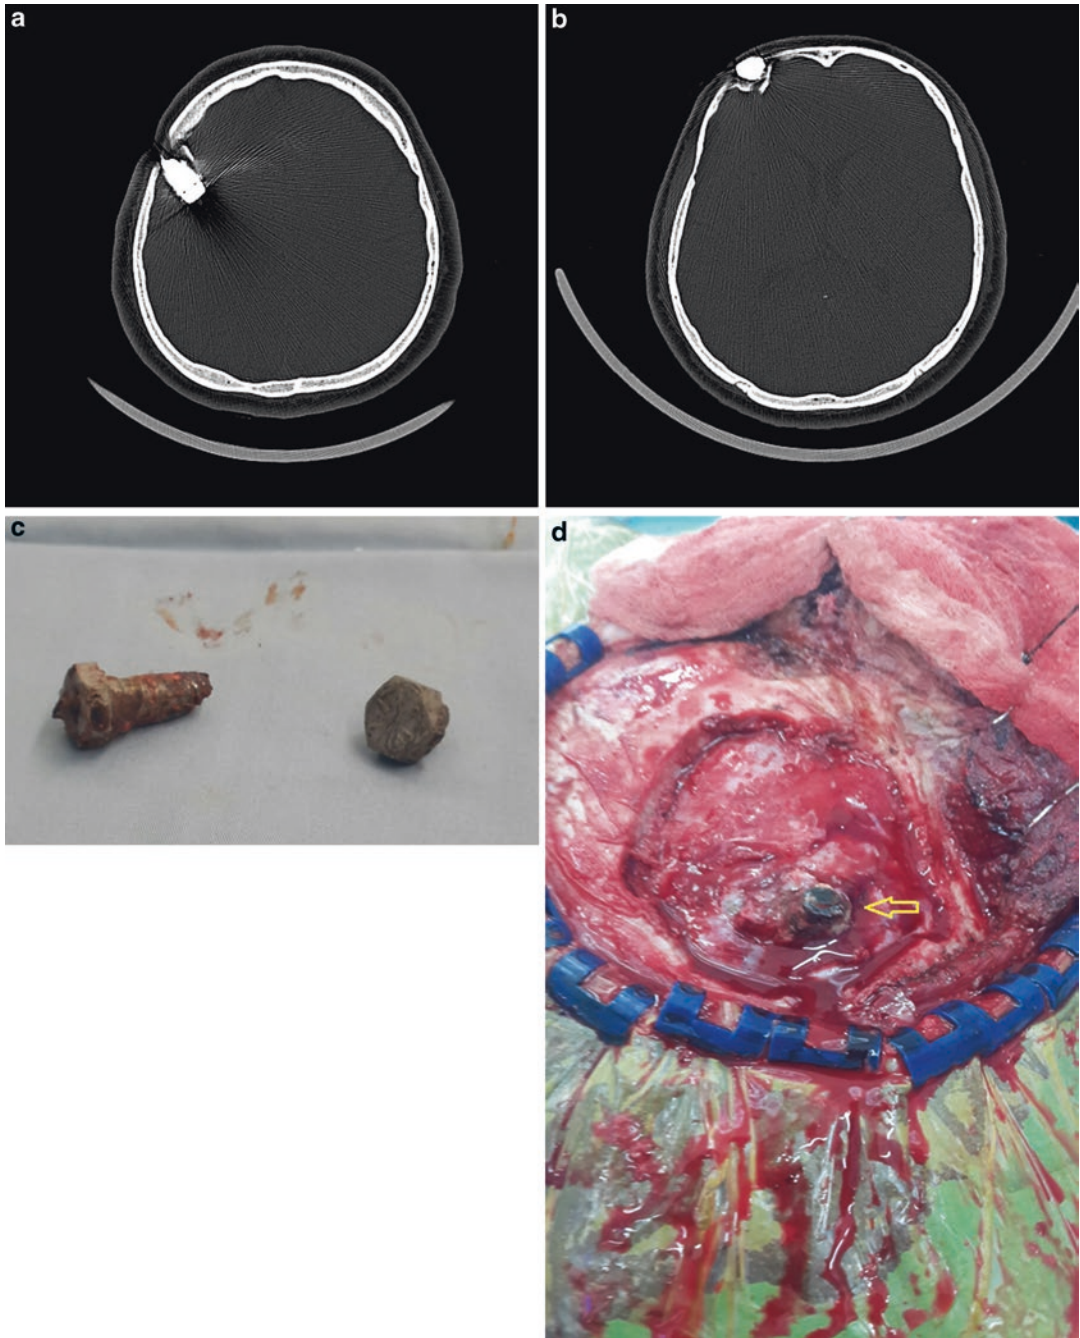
(a) CT of brain. 2.5 × 1.5 cm foreign body with right middle and inferior frontal gyri with overlying comminuted frontal bone fracture. (b) CT brain. Metallic foreign body in the subcutaneous tissue of the right frontal
